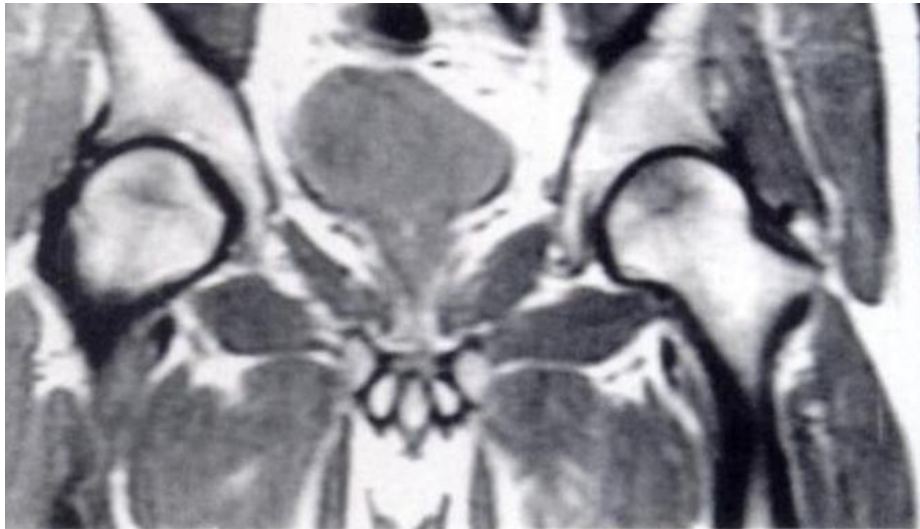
(b) MRI of Stage 0 AVN Adapted from(Anderson, 2015)
